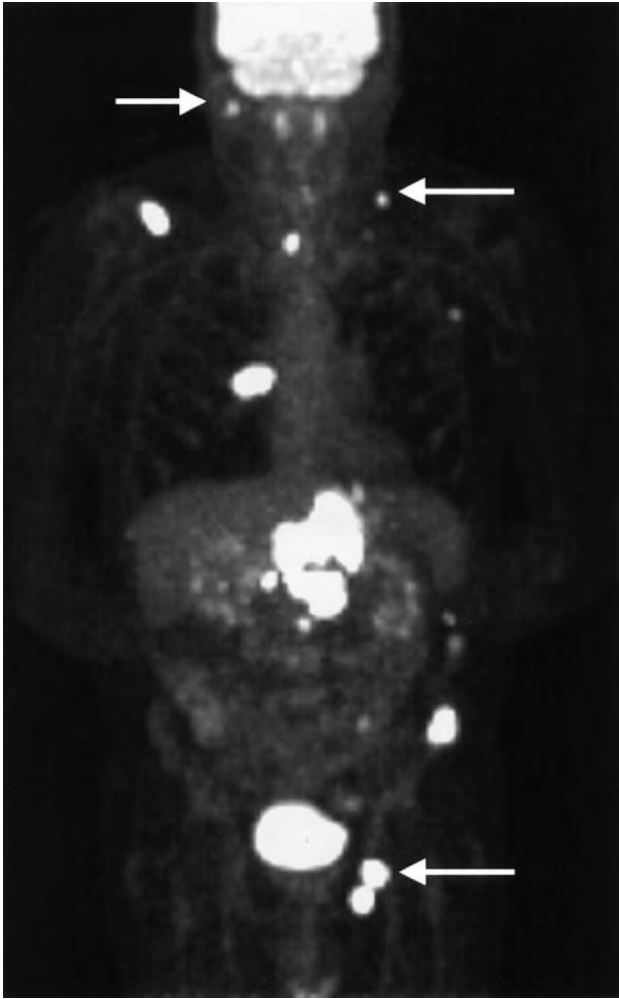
Coronal PET in a patient with esophageal cancer. Endoscopic ultrasound had revealed the tumor and suspicious peritumoral nodes, but no biopsy of the nodes could be performed. CT also demonstrated the tumor and suspicious gastrohepatic nodes. PET showed multiple distant metastasis not otherwise described, some of which, right neck, left supraclavicular, and left groin areas (arrows), would be easily accessible for biopsy.
